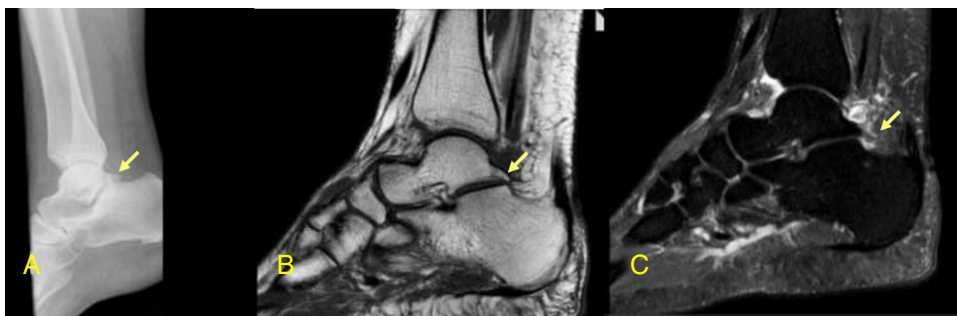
Lateral right ankle radiography (A), T1 weighted sequence (B) and sagittal STIR MRI sequence (C) images demonstrating an enlarged Stieda's process (arrows) with mild bone marrow and soft tissues edema.
